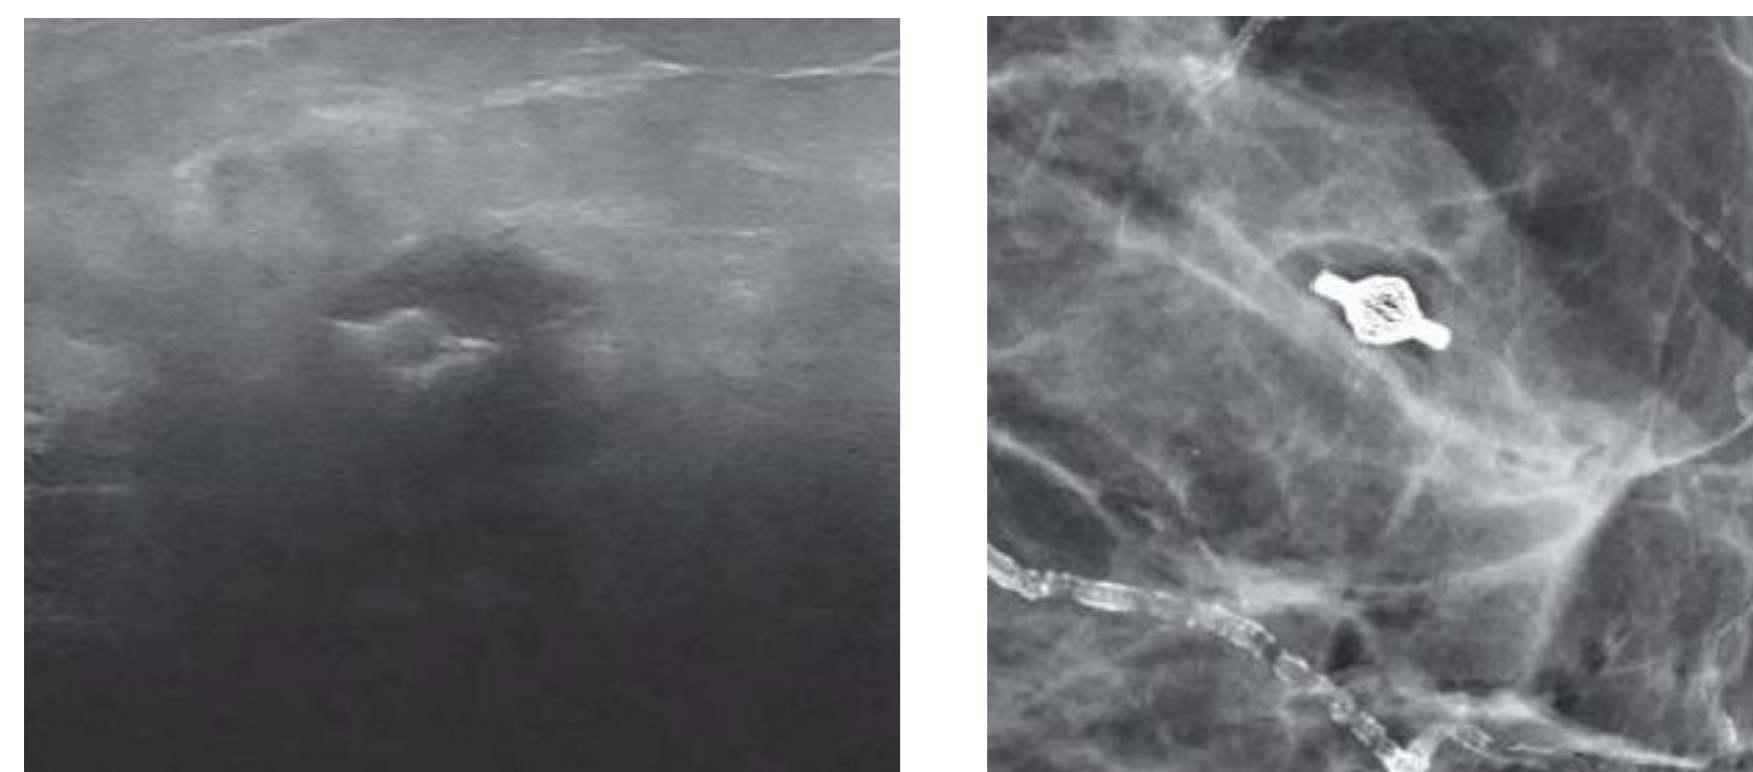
Visibility of the Tumark® Vision clip on ultrasound (left) and mammography (right) images.
